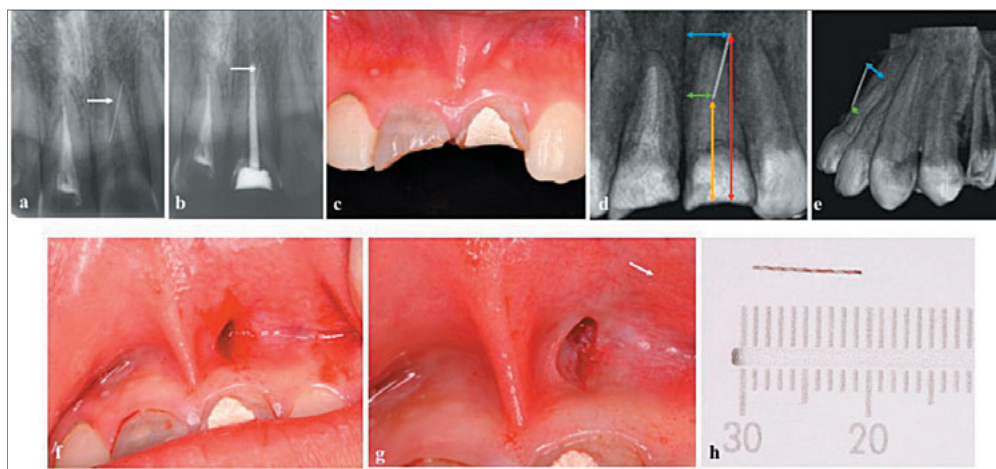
(a) A periapical radiograph revealed a fragment lying near the middle third of the root of the maxillary left central incisor (white arrow). (b) The fragment remained in the same position after root canal treatment on the maxillary left central incisor (white arrow). (c) The maxillary central incisors had crown fractures, and temporary filling material could be seen. (d) The measurements between the fragment and the incisive canal were 2.9 mm (green arrow) and 4.3 mm (blue arrow), and those between the fragment and the fractured margin were 11.7 mm (orange arrow) and 20.2 mm (red arrow). (e) The measurements between the fragment and the convex surface of the labial cortical plate of the maxillary left central incisor were 0.8 mm (green arrow) and 3.6 mm (blue arrow). (f) A small vertical incision was made based on the CBCT images. (g) The fragment was located in the mucosa (white arrow). (h) Retrieval of the fragment.
